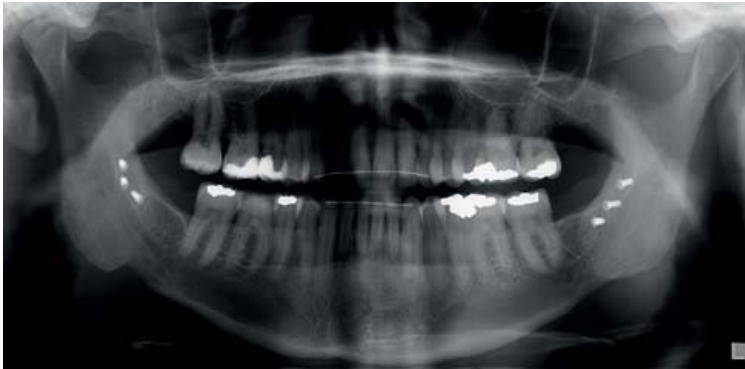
Orthopantomographic image acquired a year after BSSO, showing an osseous inferior border defect on the right side.
